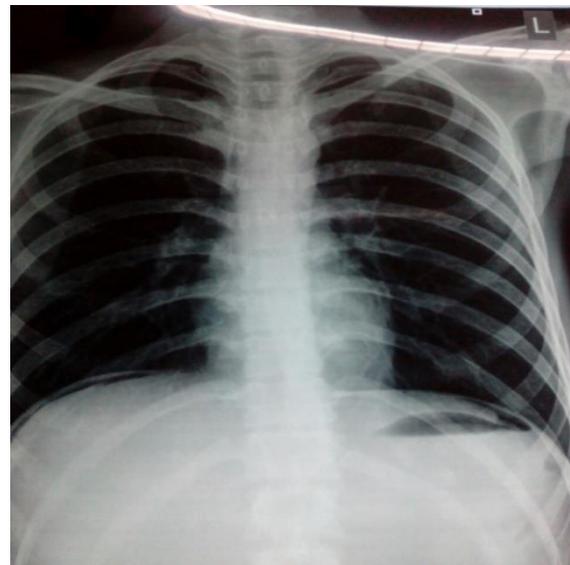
Chest X-ray showing free gas under both domes of diaphragm
